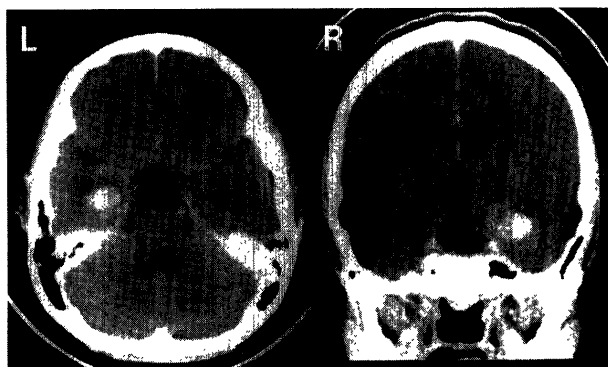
Case 1. Preoperative postcontrast CT scans, showing a high-density mass in the left medial temporal lobe.
